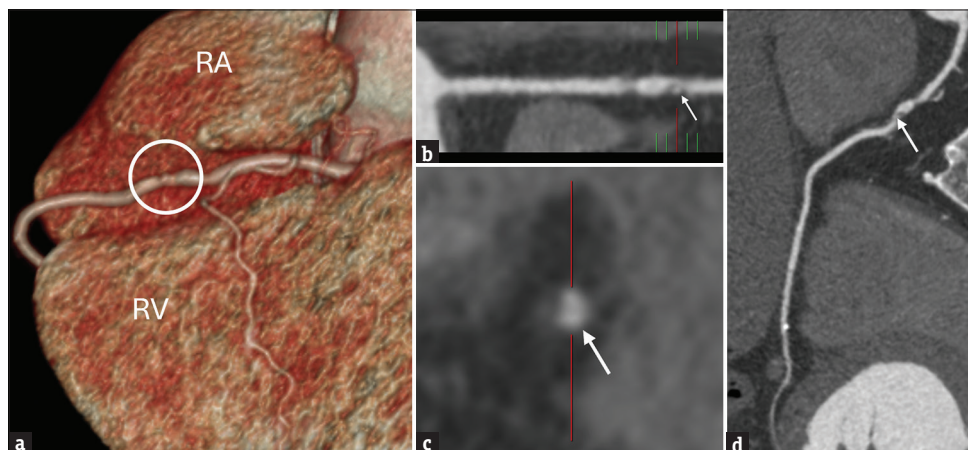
Coronary computed tomography angiography of a 56-year-old man. It showed severe (70%–95%, white circle) stenosis in the right coronary artery (RCA), confirmed by volume-rendering (a) as well as multiplanar reconstruction (b-d). Note spotty calcifications (arrow) in the plaque of RCA, implies vulnerable plaque. RA: Right atrium, RV: Right ventricle
